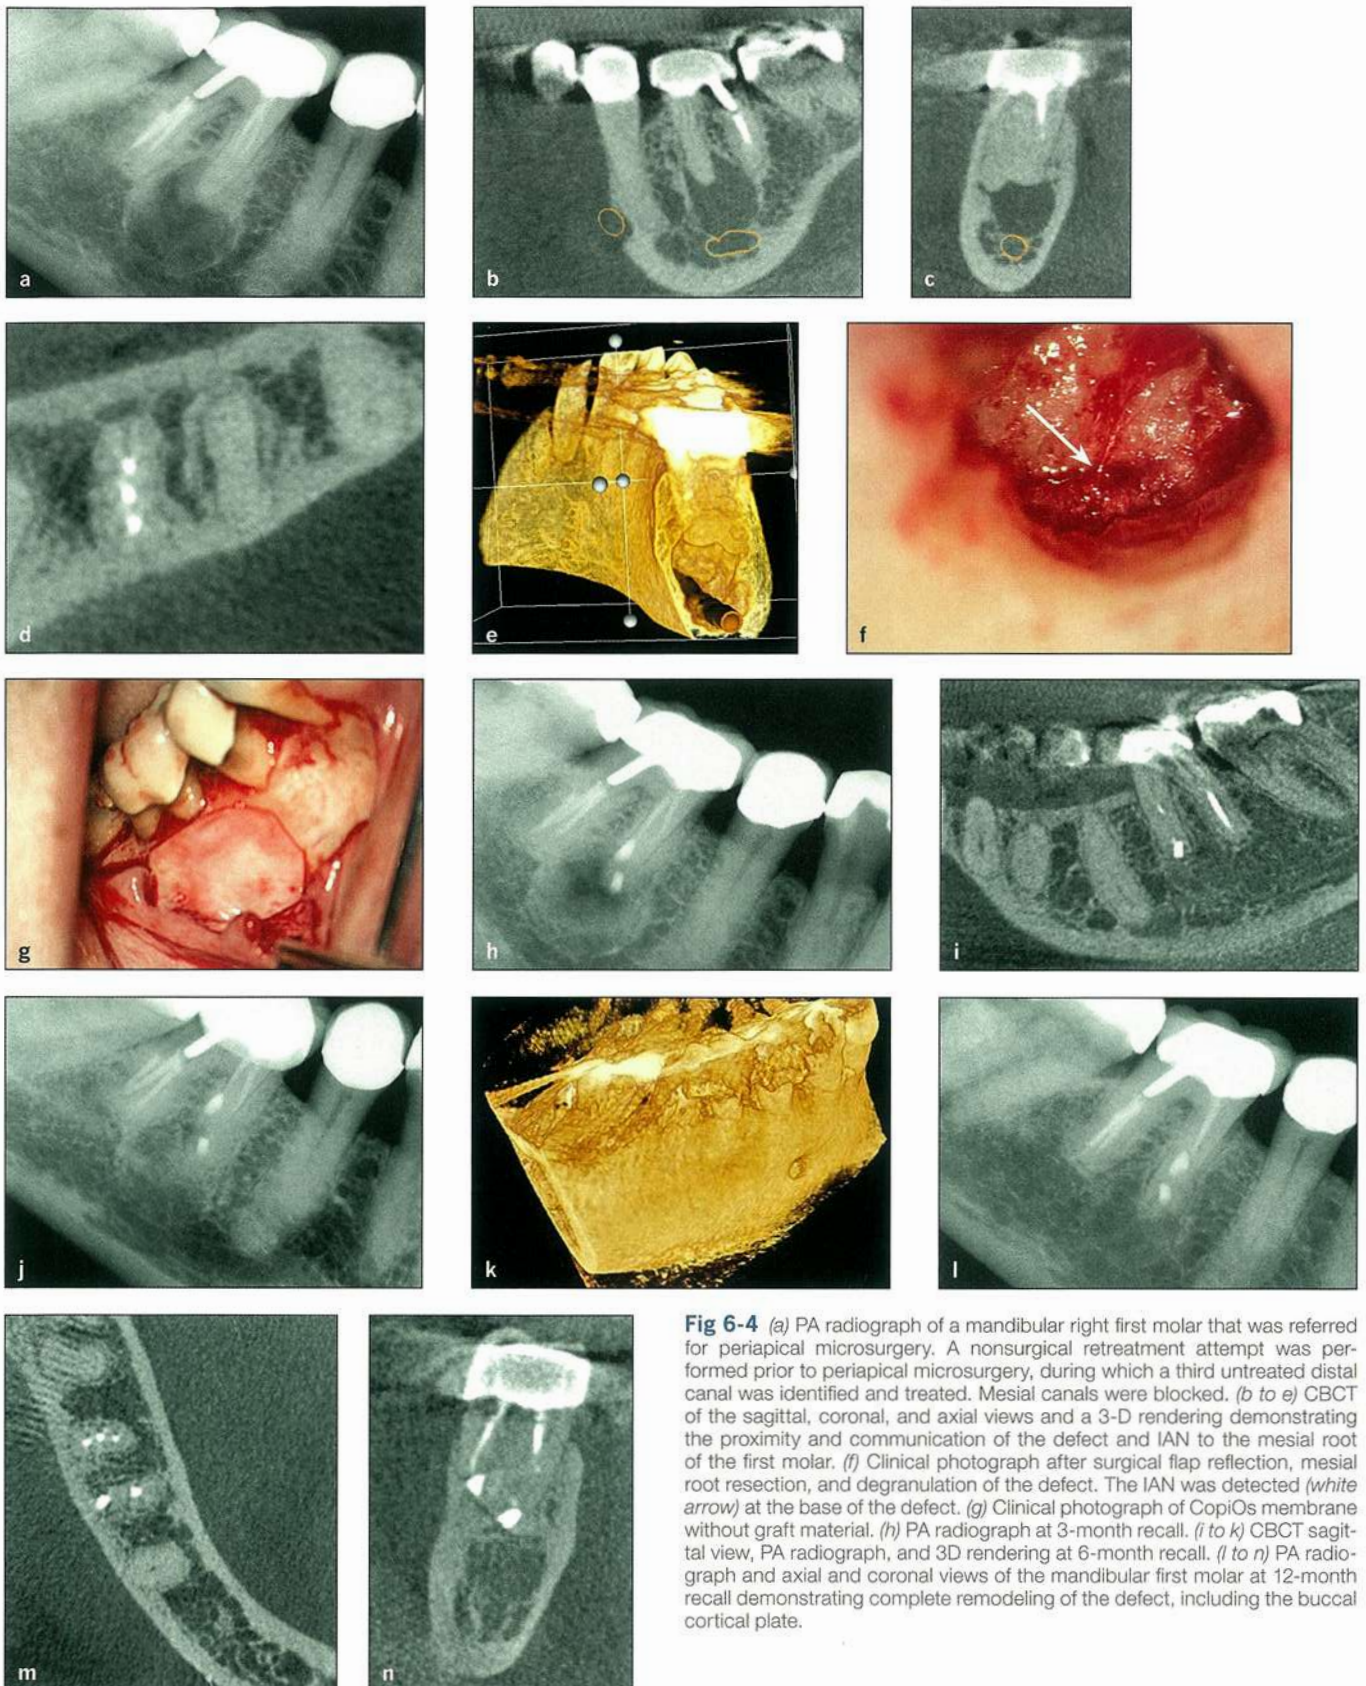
(a) PA radiograph of a mandibular right first molar that was referred for periapical microsurgery. A nonsurgical retreatment attempt was performed prior to periapical microsurgery, during which a third untreated distal canal was identified and treated. Mesial canals were blocked. (b to e) CBCT of the sagittal, coronal, and axial views and a 3-D rendering demonstrating the proximity and communication of the defect and IAN to the mesial root of the first molar. (f) Clinical photograph after surgical flap reflection, mesial root resection, and degranulation of the defect. The IAN was detected (white arrow) at the base of the defect. (g) Clinical photograph of CopiOs membrane without graft material. (h) PA radiograph at 3-month recall. (i to k) CBCT sagittal view, PA radiograph, and 3D rendering at 6-month recall. (l to n) PA radiograph and axial and coronal views of the mandibular first molar at 12-month recall demonstrating complete remodeling of the defect, including the buccal cortical plate.
